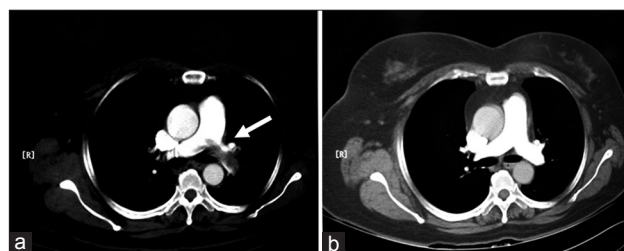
Chest computed tomography with contrast medium: the arrow pointing to the filling defects 1 day later after radiofrequency catheter ablation (a) and the dissolution of pulmonary embolism after 3 months of anticoagulation therapy (b).
